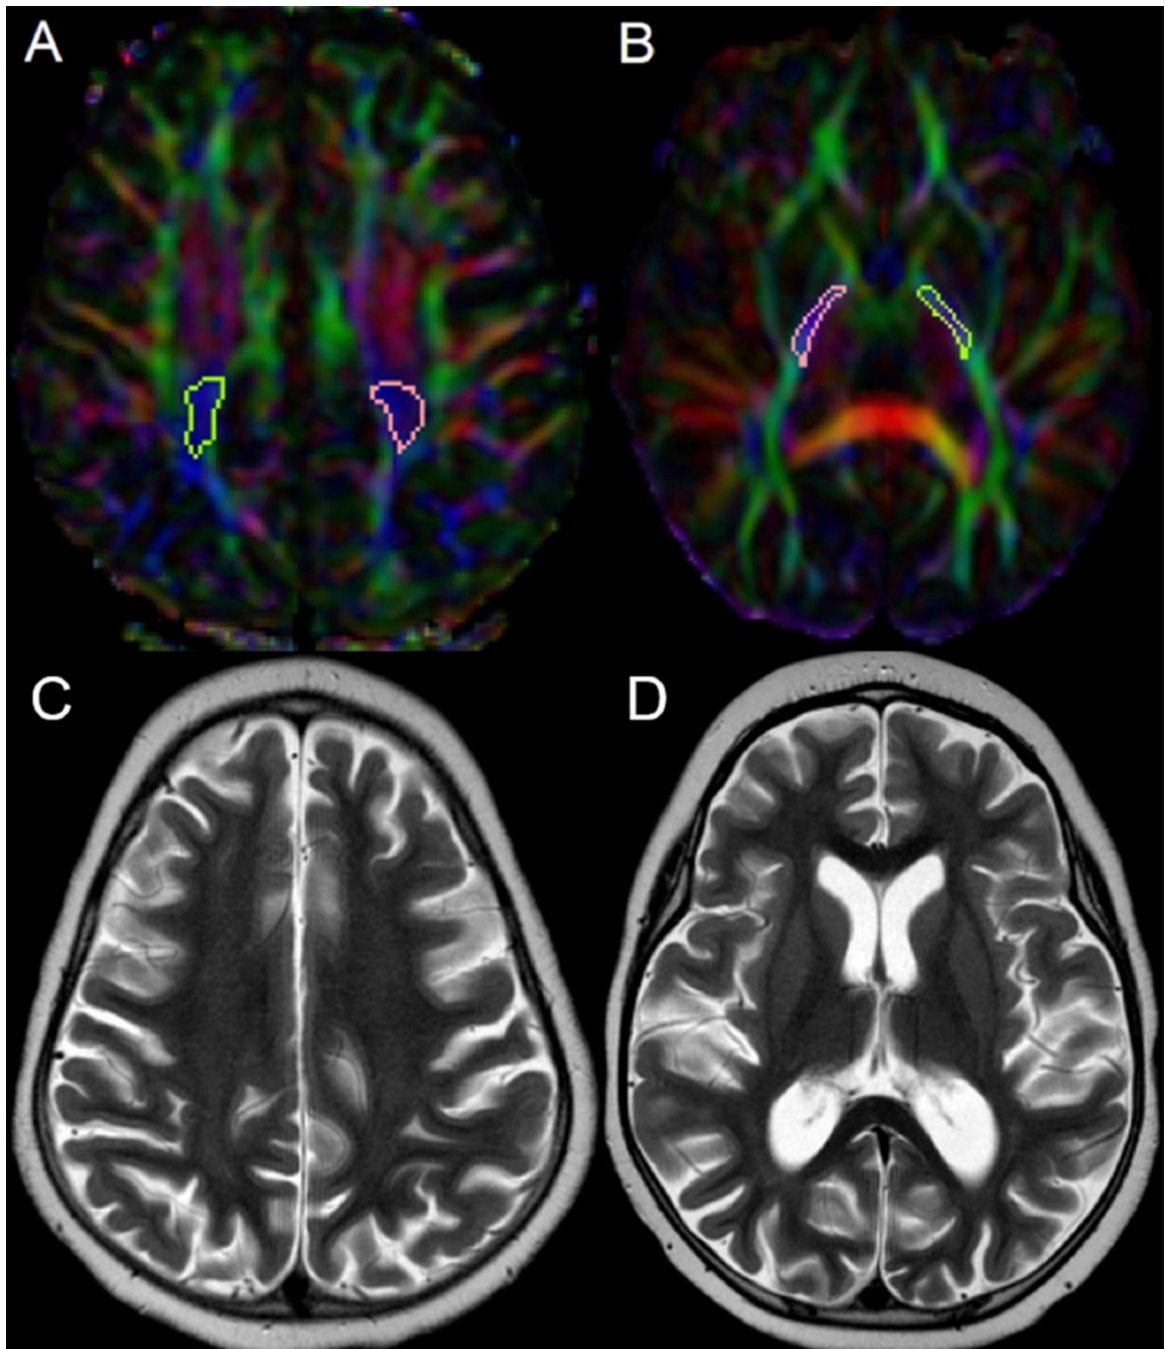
Axial color-coded fractional anisotropy (FA) maps (A, B) show the position of the regions of interest covering the bilateral posterior limb of the posterior centrum semiovale (PCSO) and internal capsule (PLIC). Axial T2-weighted images of the same patient at the level of the PCSO (C) and PLIC (D).
